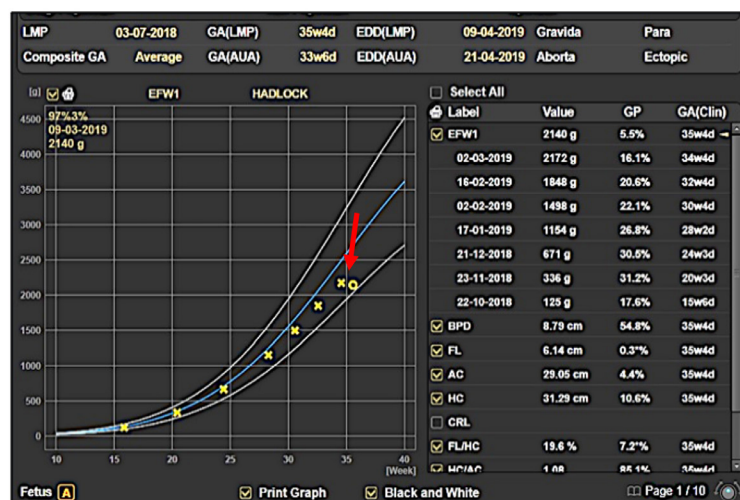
Growth chart. Ultrasound examination results for the 6<sup>th</sup> pregnancy. The fetal growth chart showed that fetal weight decreased at 35 weeks (red arrow).
